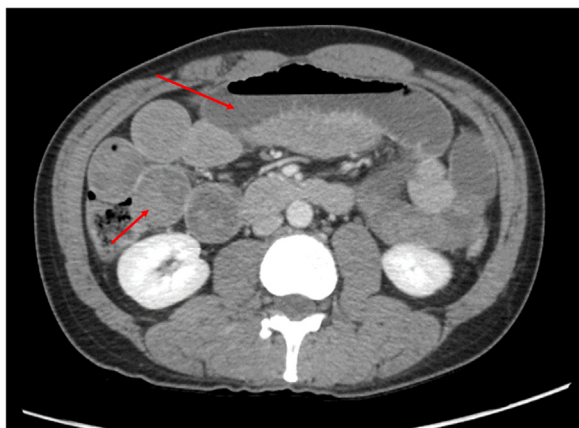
Computed tomography abdomen/pelvis scan showing dilated loops of small bowel with small amounts of layering of hyperdense contents concerning for hemorrhage vs. ingested material (red arrows).
